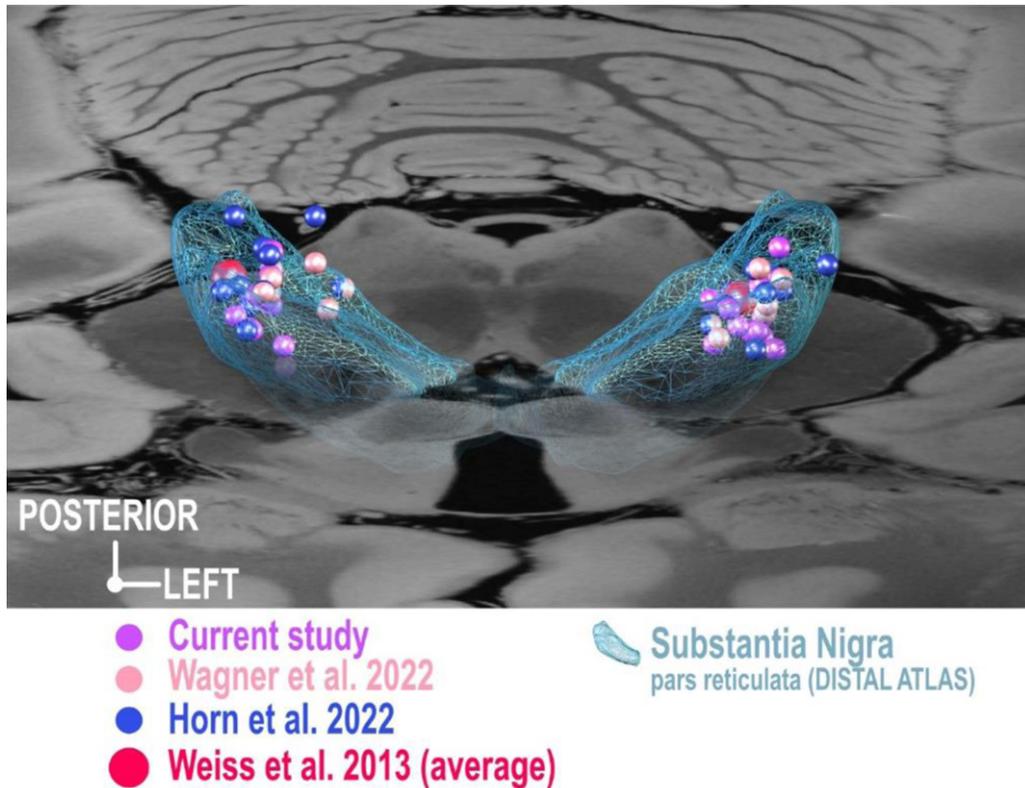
3D-visualization of previously published coordinates of electrodes targeting the substantia nigra from two studies [15, 17] as well as the cohort average of one study [18]. As coordinates for these studies were reported relative to AC-PC, an established conversion algorithm [62] was used to project coordinates into a common space (MNI) and relative to the substantia nigra atlas structure as defined by the DISTAL atlas [32] superimposed on a slice of 7 Tesla MRI of ex vivo human brain at 200 micron resolution [61]. Note that coordinates aggregate in the dorsolateral substantia nigra or even dorsal to the substantia nigra within the region of the subthalamic nucleus.
